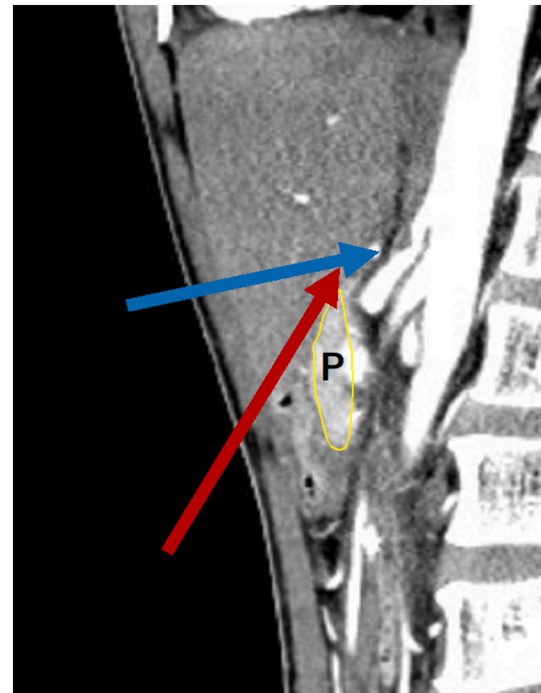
Enhanced three-dimensional computed tomography scan showed the location of celiac artery and pancreas. Forceps from the caudal side was obstructed by the pancreas (red arrow).
